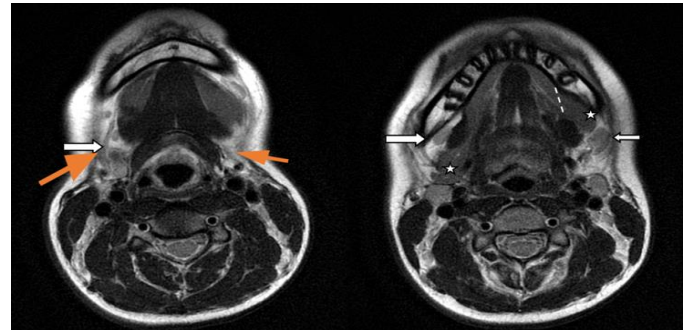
Axial T2W MRI images showing (A) Absence of bilateral submandibular glands. Only fat, facial vessels (orange arrows in (a)) and lymph node (white arrows in (a, b)) present at the expected location for submandibular glands. (B) Hypertrophied right sublingual gland (star) extending into right submandibular area and hypertrophied left sublingual gland (star) herniating through ipsilateral anterior mylohyoid muscular defect (dotted line in (b)).
